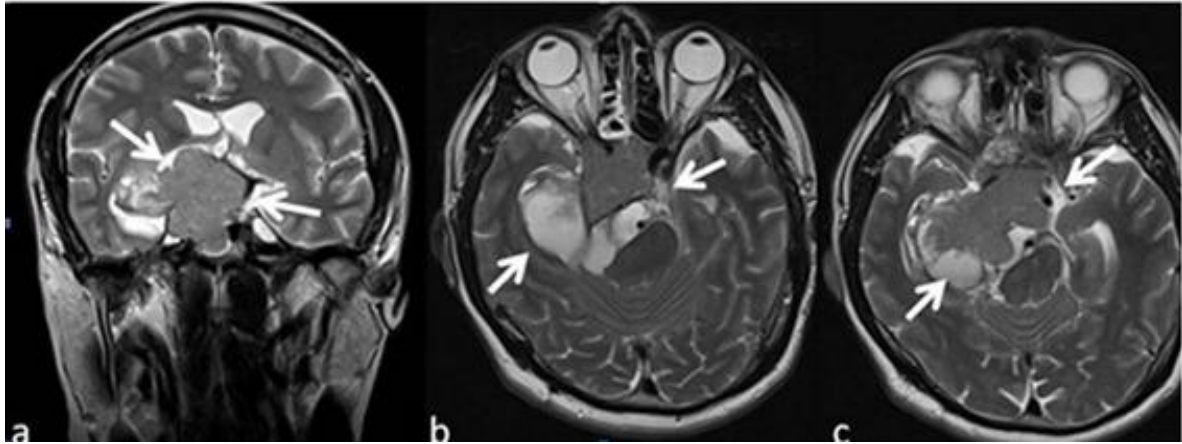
T2-weighted coronal (a) and axial (b, c) MR images obtained in 2019, showing a giant solid-cystic mass filling the sella turcica and extending into the suprasellar cistern (white arrows).
